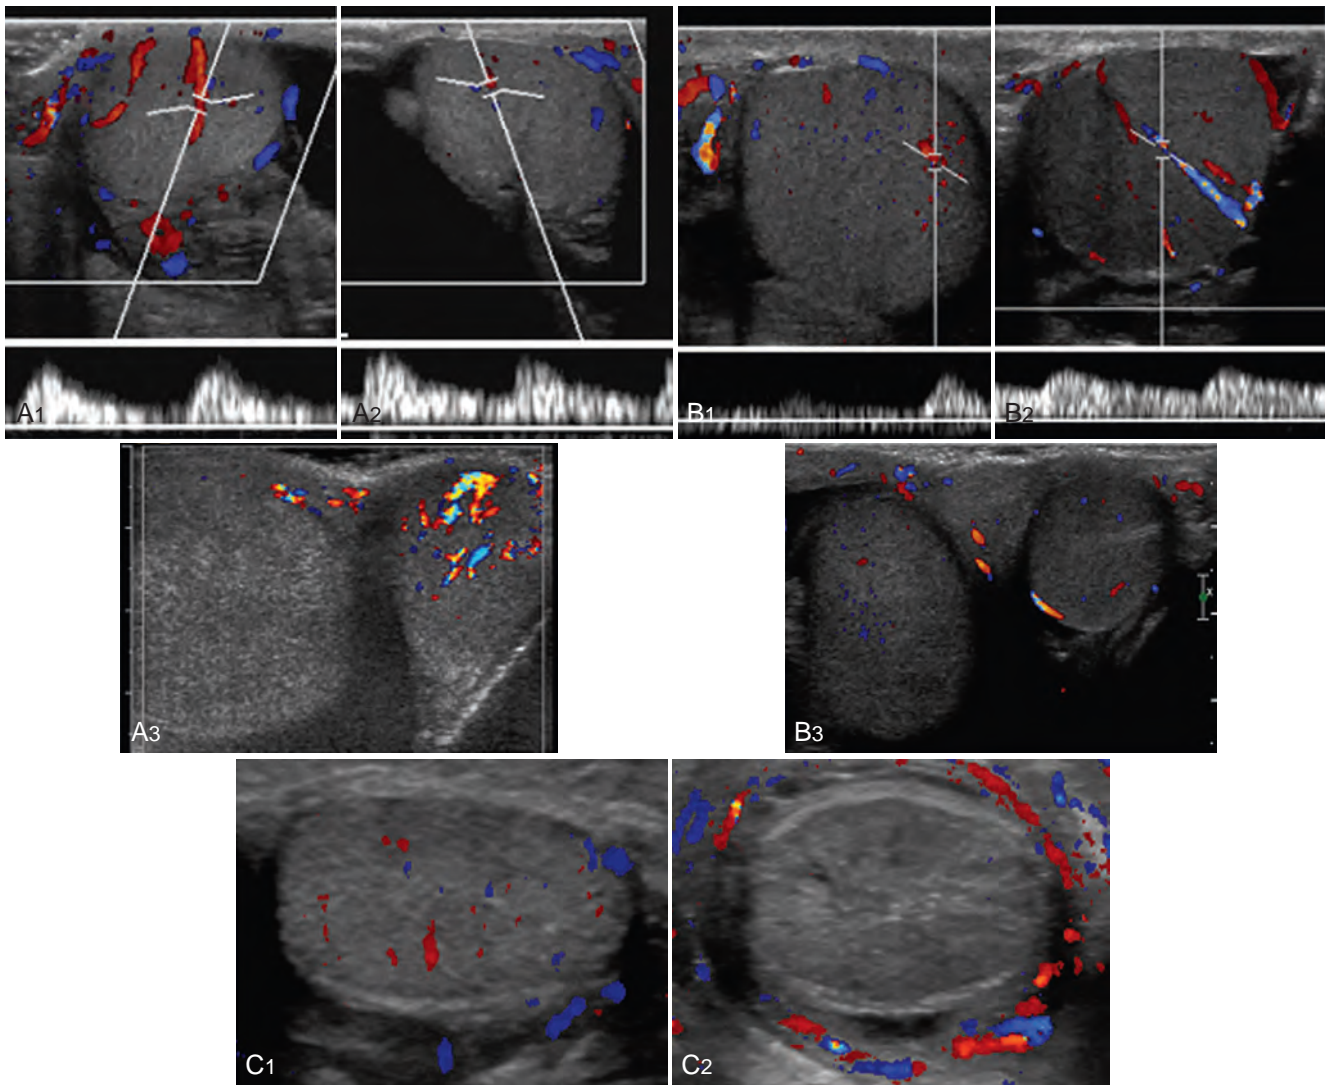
Imaging of intravaginal spermatic cord torsion. A, Intermittent torsion. Color Doppler ultrasonography (CDUS) demonstrates preserved arterial flow to testis with 12 hours of pain and then loss of flow and parenchymal heterogeneity when child returned later with worsening pain. B, Acute torsion with reduced arterial flow. C, Prolonged torsion. CDUS shows heterogeneous testis without arterial or venous flow and a hyperechoic parenchymal ring.
